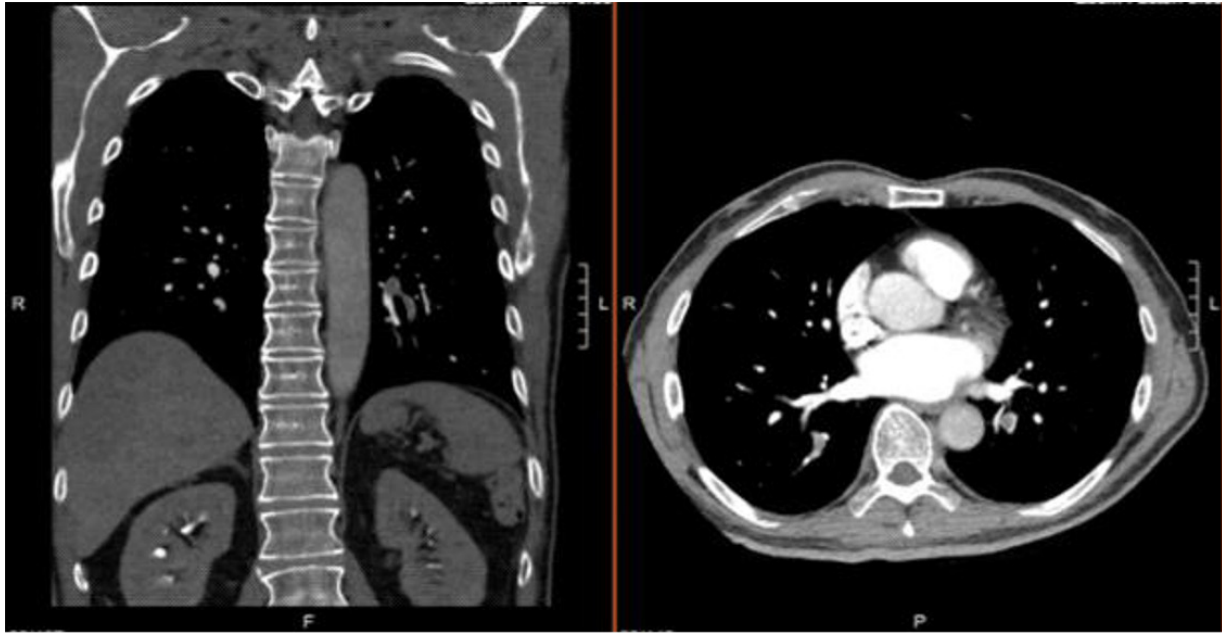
CT pulmonary angiography, performed July 1, 2025, showing multiple bilateral segmental pulmonary emboli; no concurrent pleural effusion is present. CT, computed tomography.
